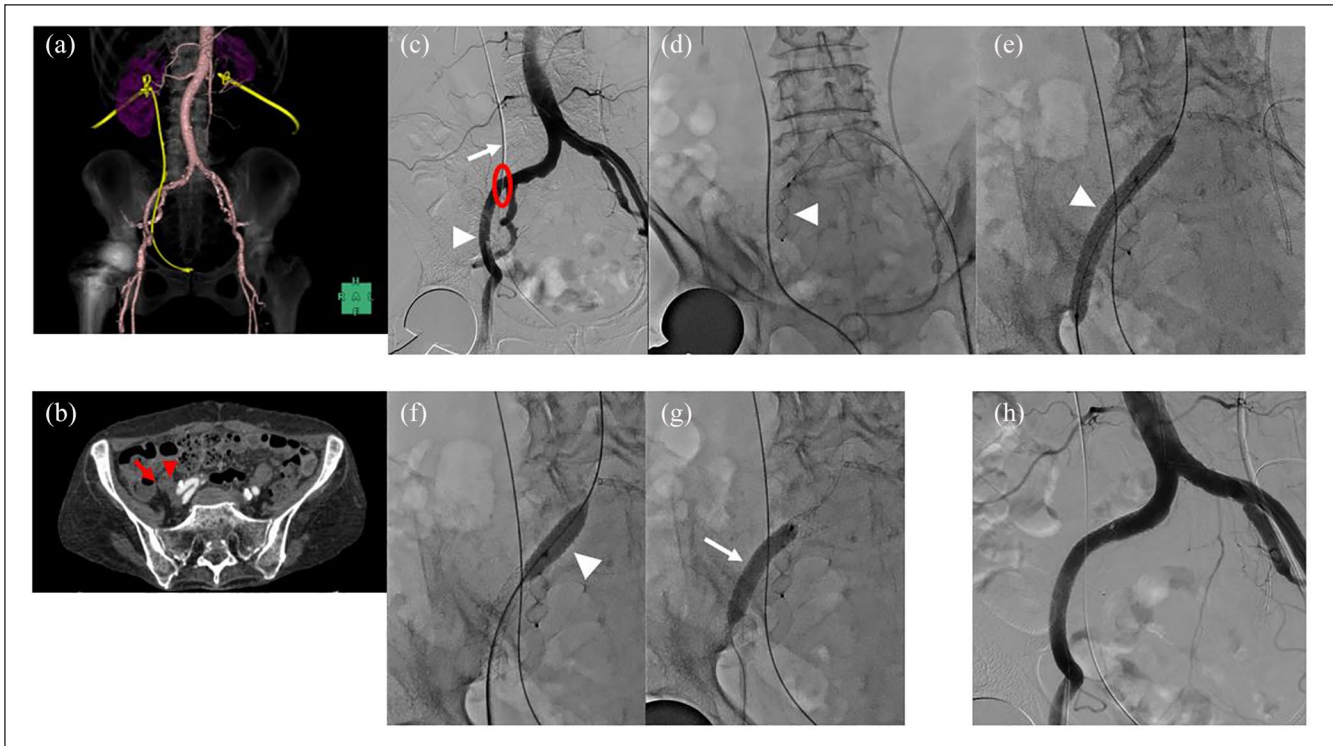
(a) CT angiography (coronal plane). (b) CT scan showing that the right ureter (red arrow) coursed above the right EIA (red arrowhead) and was in contact with the EIA. (c) Aortogram showing no contrast leak in the right ureter. The crossing point (red oval) of the right ureteral stent (white arrow) and the right EIA (white arrowhead) indicates the presence of an AUF. (d) The right IIA is embolized using a 10×7 mm vascular plug (white arrowhead) to prevent endoleak. (e) The 7×79 mm GORE® VIABAHN® VBX Stent Graft (white arrowhead) inserted with nominal pressure with its proximal apposition site within the CIA and the distal apposition site within the EIA. (f) Post-dilatation performed at the CIA with a 10×20 mm balloon catheter (white arrowhead). (g) Post-dilatation performed at the EIA with an 8×40 mm balloon catheter (white arrow). (h) No contrast leakage. Moreover, the IIA is well embolized, and the VBX is well dilated.
